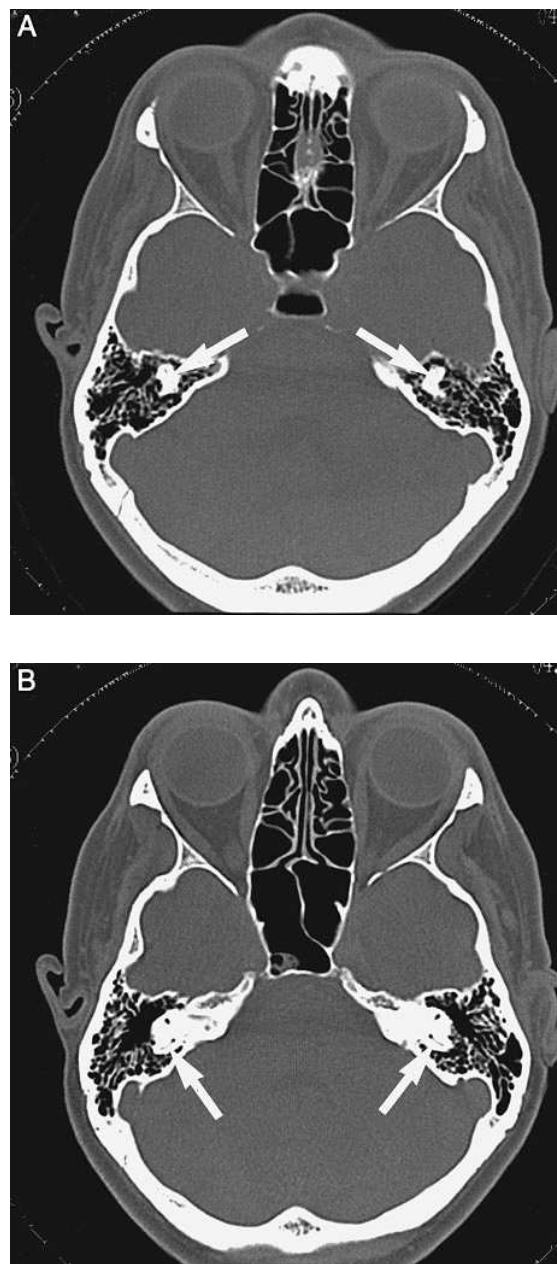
Axial CT scans of the skull demonstrating that the anterior and posterior SCCs are oriented diagonally within the temporal bones (A) The left and right anterior SCCs are shown (arrows) (B) CT scan of the same subject, 4 mm caudal to A which shows the left and right posterior SCCs (arrows)
